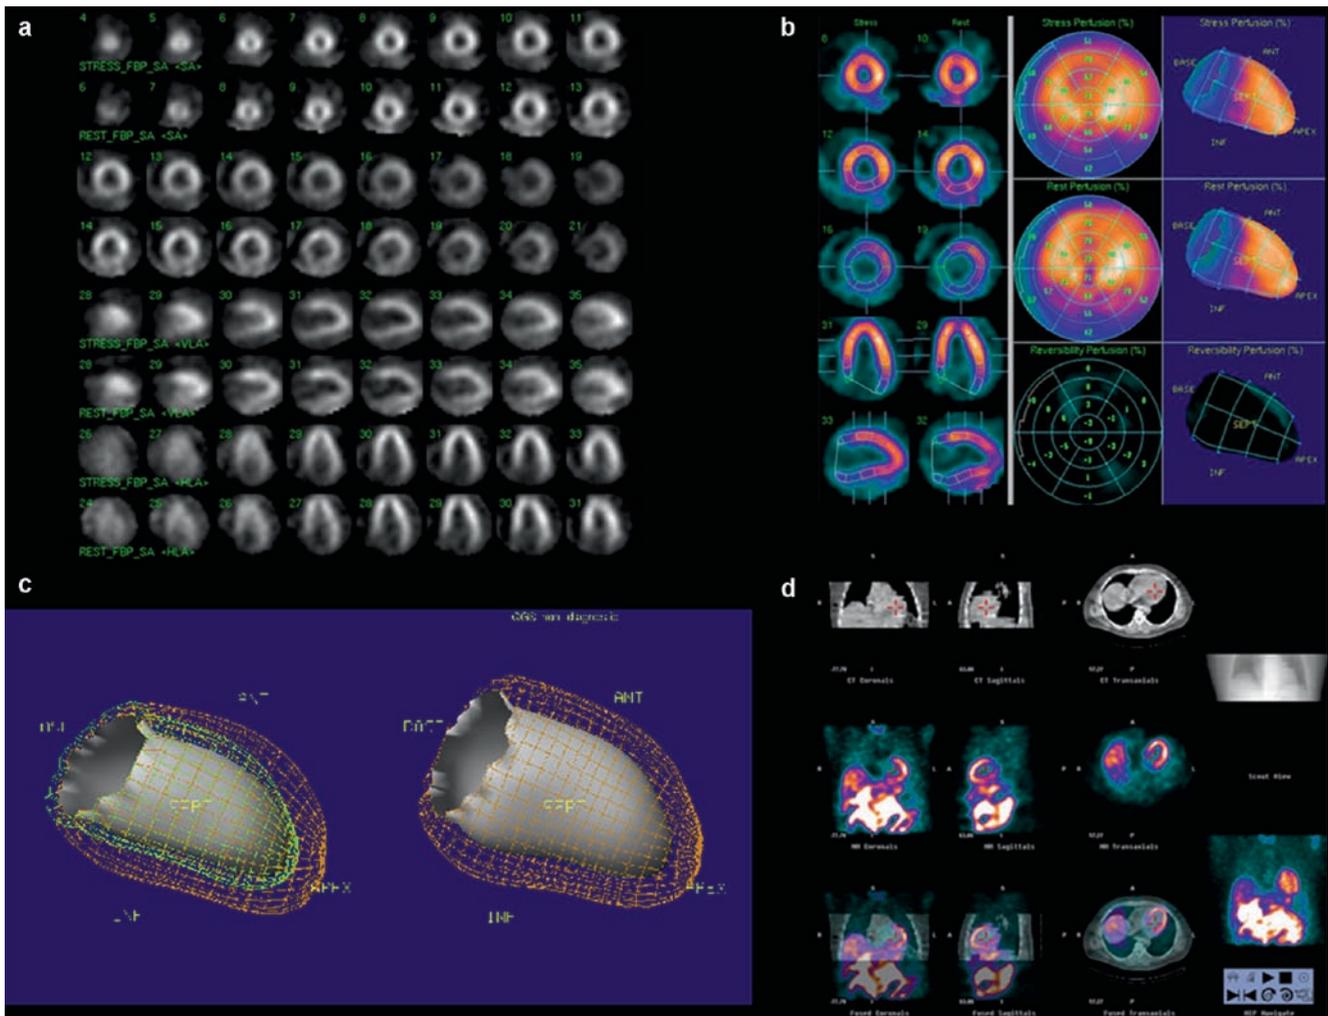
State-of-the-art myocardial SPECT imaging. (a) Display of matched stress (rows 1, 3, 5, 7) and rest (rows 2, 4, 6, 8) tomographic images, reangulated along the short and long axes of the left ventricle for visual analysis. (b) Creation of two- (middle column) and three-dimensional (3D) polar maps (right column) using software-assisted detection of myocardial contours (left column), for semi-quantitative
